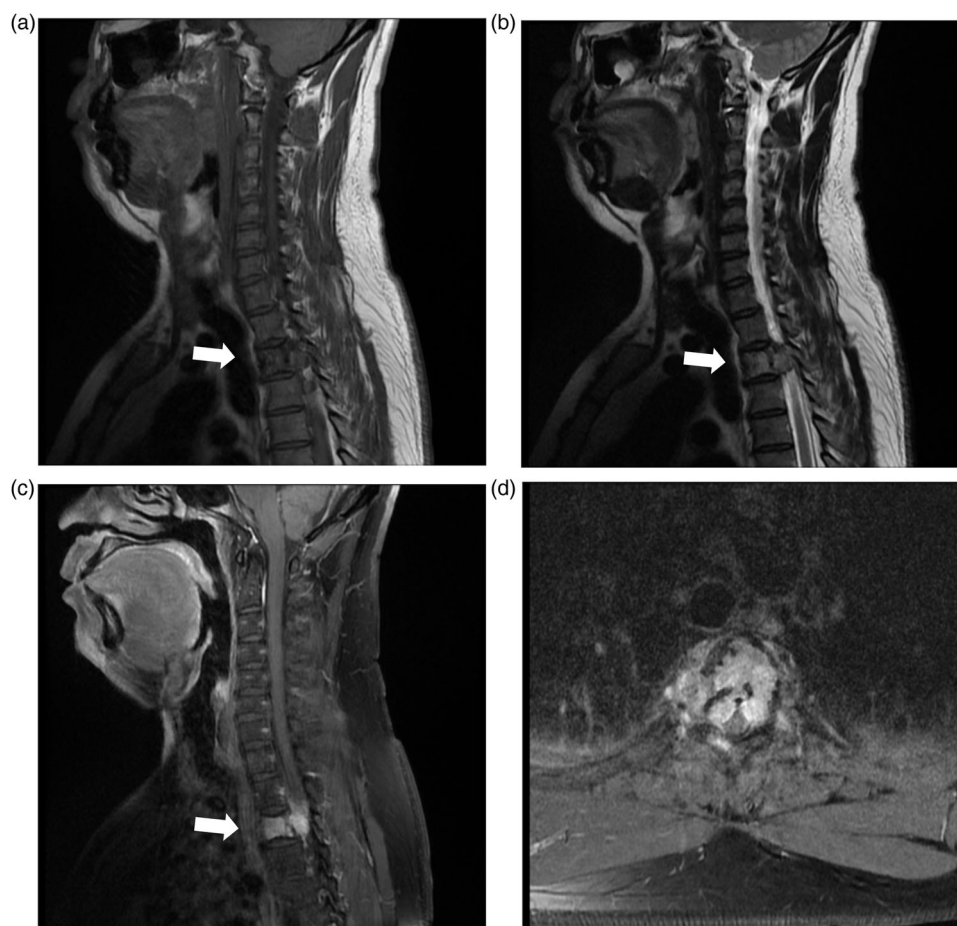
MRI of the thoracic spine shows a T1-weighted hypointense, T2-weighted hyperintense, and avid enhanced mass at the T3 level (arrow). (A) Sagittal T1-weighted image, (B) sagittal T2-weighted image, (C) sagittal enhanced image, and (D) axial enhanced image at the T3 level.
